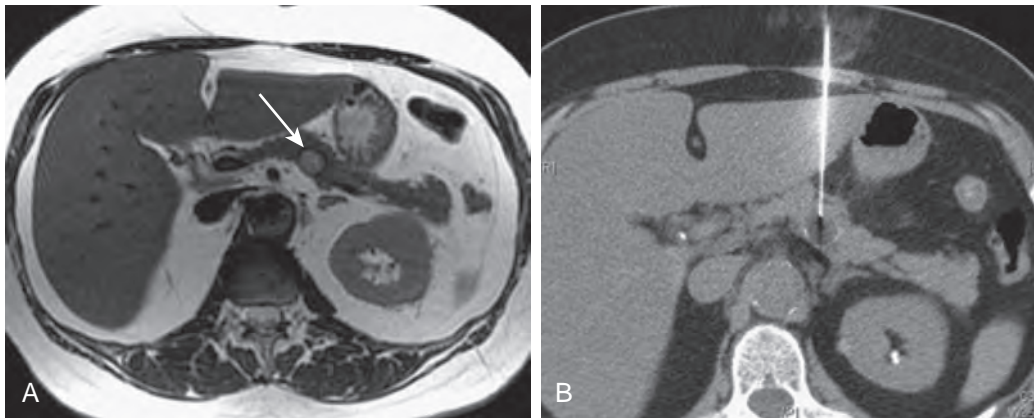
Percutaneous biopsy of cystic pancreatic neoplasm. A. Axial T2-weighted MR image shows hyperintense cystic mass (arrow) in the body of the pancreas with surrounding rim of calcifications. B. Axial noncontrast CT image shows needle sampling (22 gauge) of pancreatic mass through a transhepatic approach; cytology and subsequent fluid analysis plus molecular marking revealed benign mucinous cystic tumor with indolent cytogenetics.
